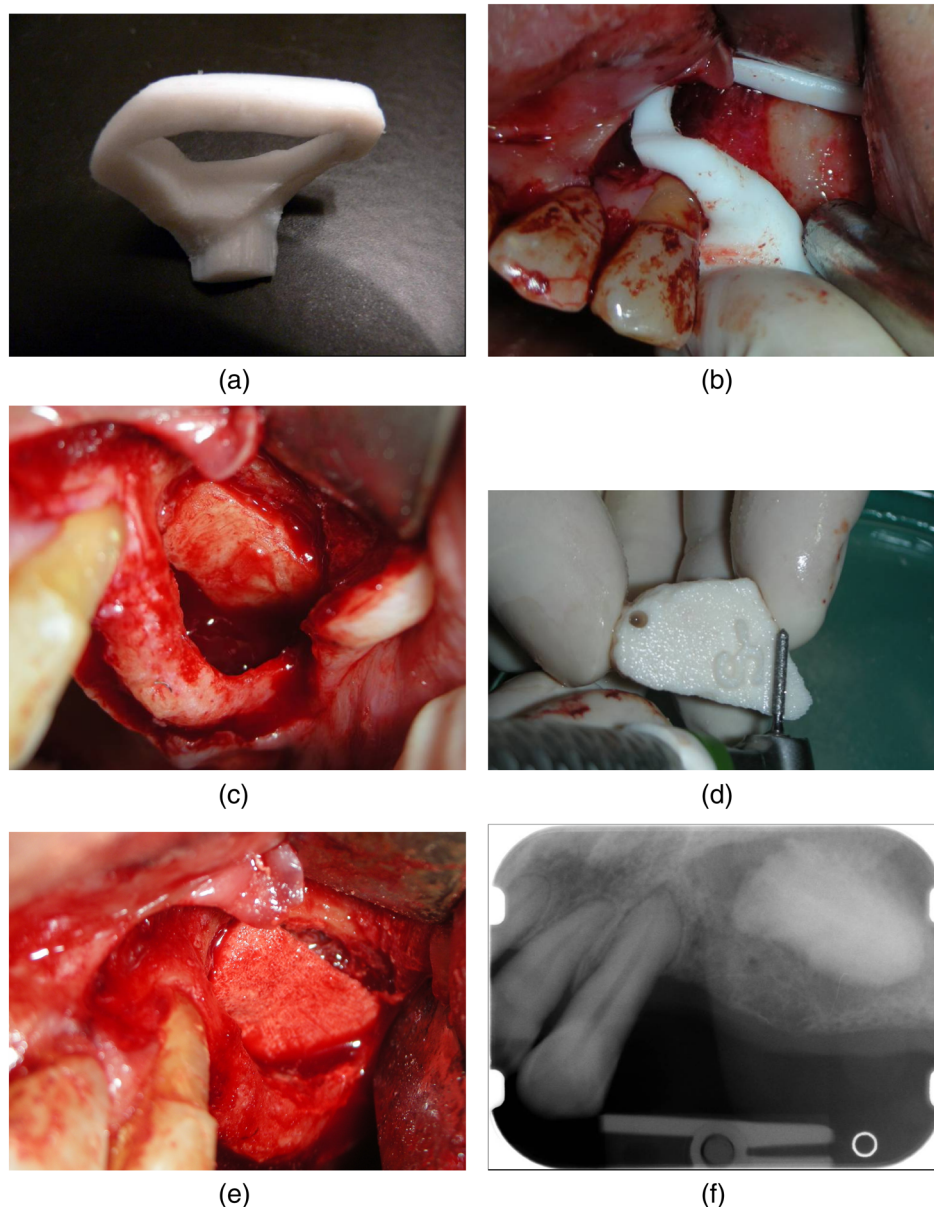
Surgical procedure: (a) PTFE customized cutting guide post manufacture, prior to insertion; (b) the PTFE customized cutting guide is fitted to the underlying bone, verified for stability and then used to outline the planned configuration of the lateral wall; (c) the bony window fragment is moved mesially, the sinus membrane is reflected and separated from the bony surface of the sinus floor with an elevator, and the space created; (d) the anatomically-shaped, custom made HA block is removed from its support and ready for use; (e) the custom-made HA block is inserted into the sinus. The block fits securely to the residual bone, immediately filling the whole empty space; (f) periapical radiograph taken immediately after maxillary sinus elevation, showing the HA block that completely fills the defect
